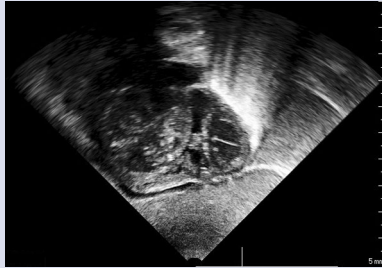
Transthoracic echocardiography right ventricular tumour
